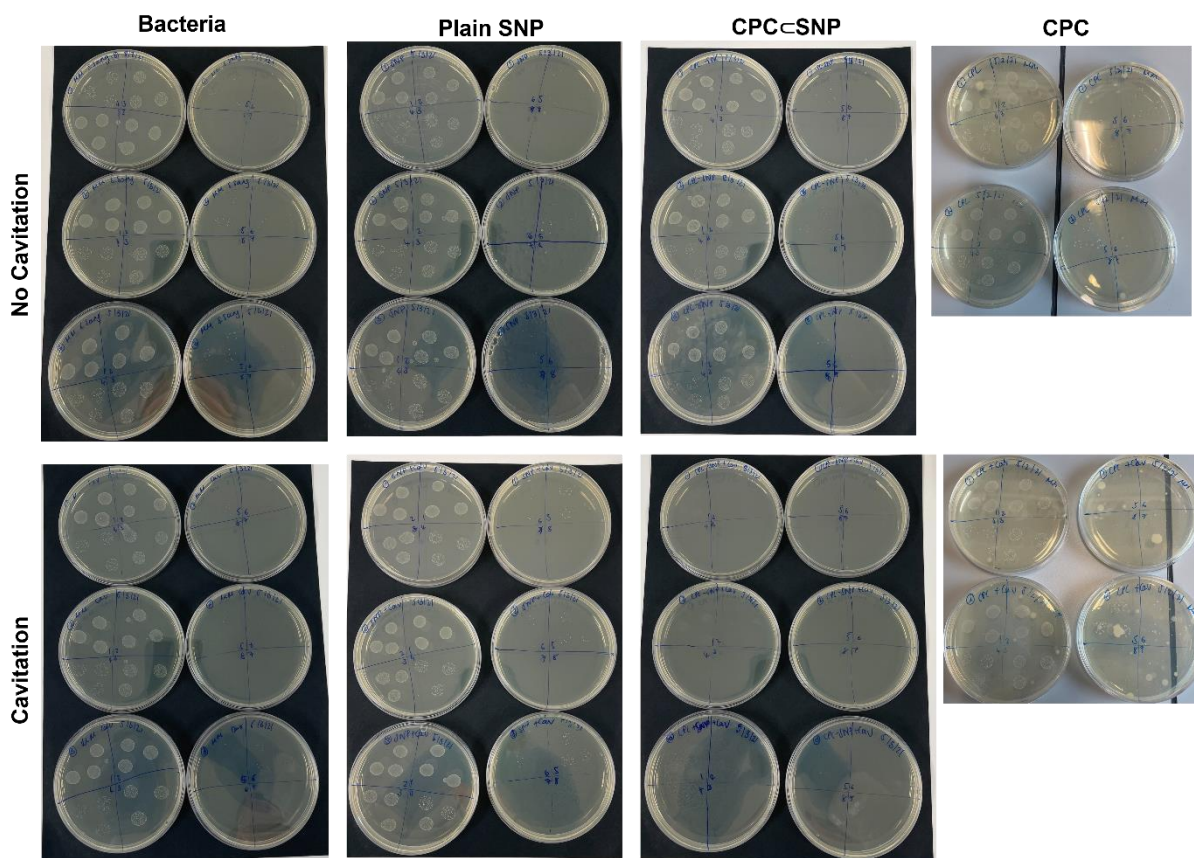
7: Images taken of colonies grown on BHI agar after treatment of *S. sanguinis* biofilms: no treatment, Plain SNP, CPC-SNP and CPC. Each were compared to no US and US triggered by ultrasonic scaler at P10, 10s. The biofilms were removed from coverslips and resuspended in BHI broth. Bacterial suspensions were plated on BHI agar after serial dilution series. Plates were incubated for 24 h at 37 °C in 5 % CO₂ conditions. Colony count was determined as colony forming units of *S. sanguinis*. Repeated in triple triplicates, note not all images were taken for each sample. Biofilm treated with CPC and CPC + US images were obtained on a different experiment day.
